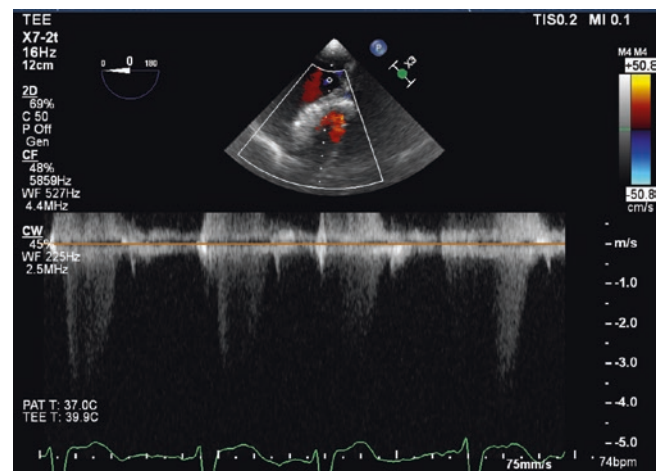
Note the faint spectral Doppler envelopes from the deep trans gastric TEE views. The Doppler envelope is poorly defined giving an unreliable estimate the mean gradient and the peak velocity is underestimated
